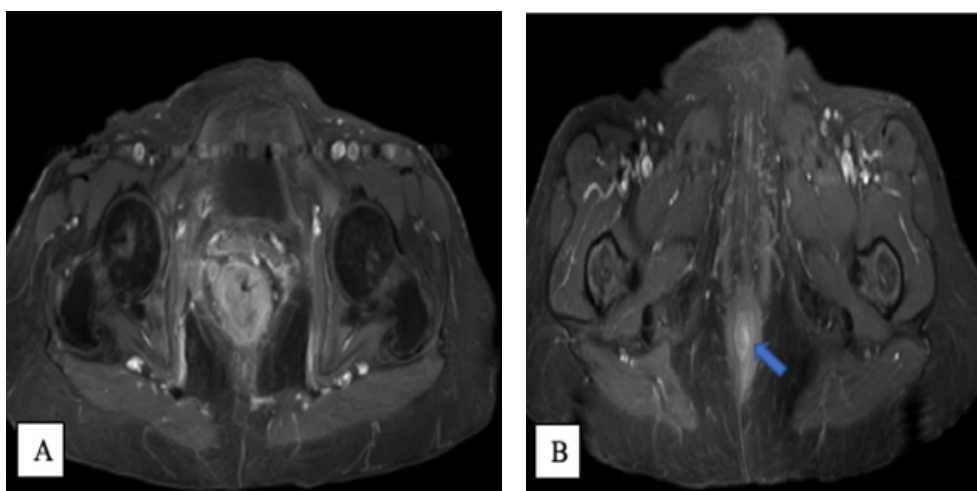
Axial sections of pelvic MRI with T1 FAT-SAT sequence after contrast injection, showing heterogeneous enhancement of the rectal tumor mass (A) and anal mass (B).
